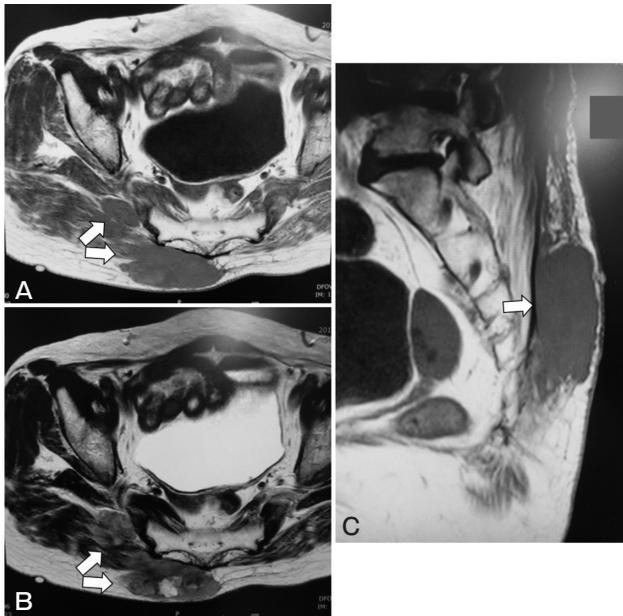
Magnetic resonance imaging (MRI) with axial views of T1-weighted (A) and T2-weighted (B) images, and an axial view (C) of the buttock. The tumor revealed an iso signal intensity on T1-weighted images and a low-to-high intensity on T2-weighted images, as indicated by the white arrows.
